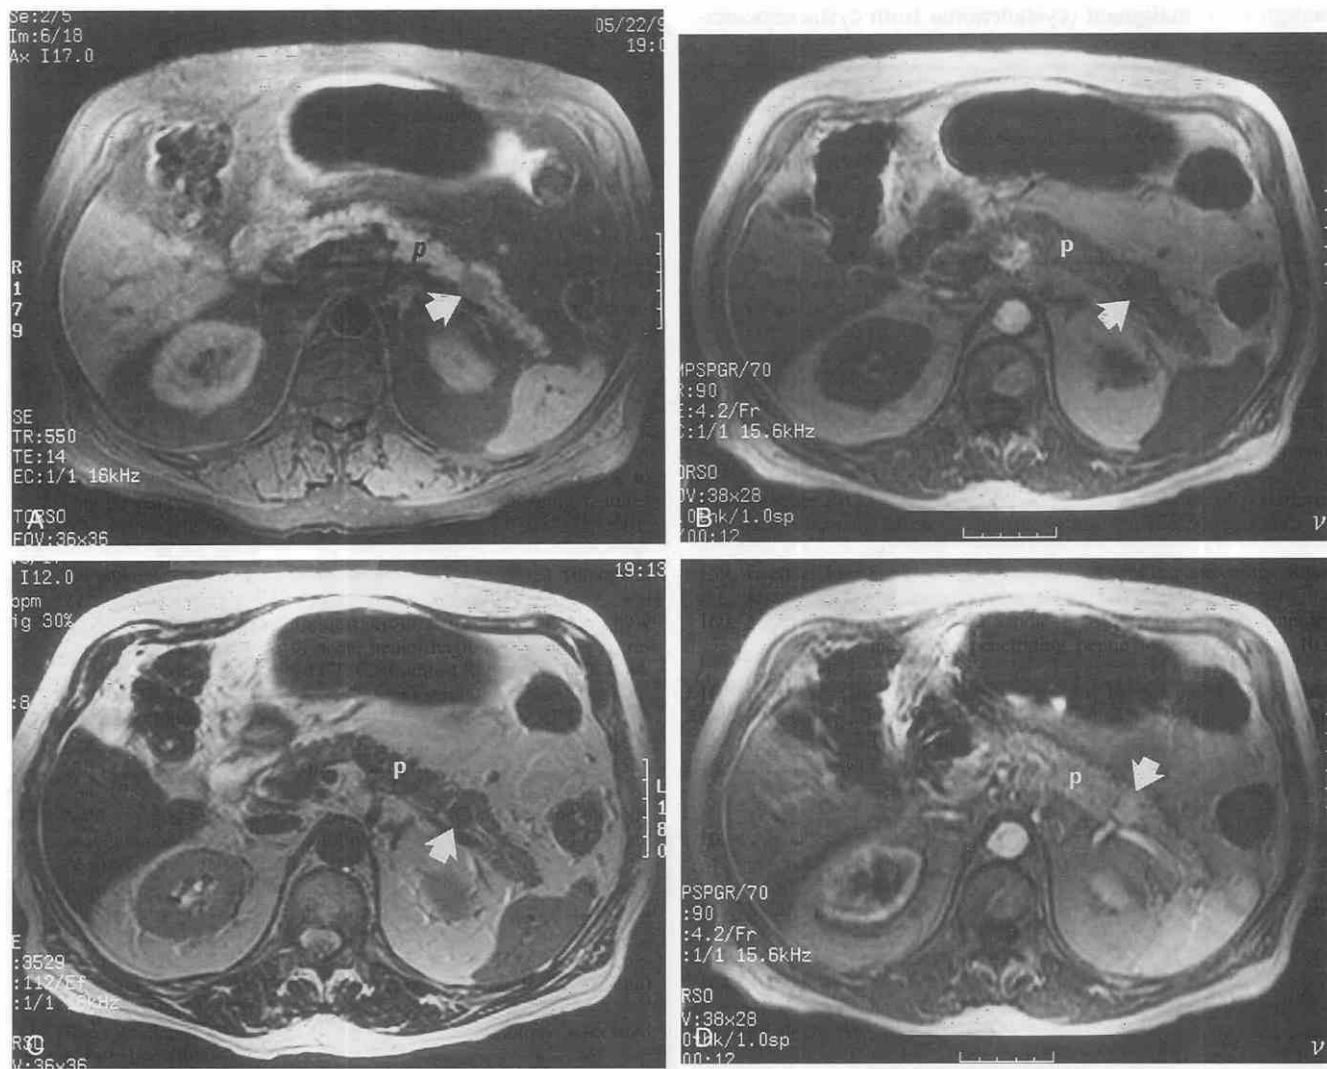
A, Transverse T1-weighted SE image (TR = 550 msec, TE = 14 msec, one signal acquired, with fat suppression) shows a 1.5-cm lesion (arrow) near the tail of the pancreas (p). CT also depicted the lesion in this patient with an insulinoma. B, Transverse breath-hold T1-weighted fast multiplanar spoiled gradient-recalled echo (GRE) image (TR = 120 msec, TE = 4.2 msec, one signal acquired, 70-degree flip angle) also demonstrates the insulinoma (arrow), but less conspicuously. p, = pancreas. C, Transverse T2-weighted fast SE image (TR = 4000 msec, TE = 102 msec/effective, three signals acquired) without fat suppression shows the lesion (arrow) as a mass of low signal intensity. p, pancreas. D, Transverse breath-hold fast multiplanar spoiled GRE image (TR = 120 msec, TE = 4.2 msec, one signal acquired) with gadopentetate dimeglumine enhancement shows the mass (arrow) as an enhancing lesion of higher signal intensity than that of the normally enhancing parenchyma (p). (From Thoeni RF, Ullrich G, Mueller-Lisse J, et al: Detection of small, functional islet cell tumors in the pancreas: Selection of MR imaging sequences for optimal sensitivity. *Radiology* 214:483-490, 2000.)
